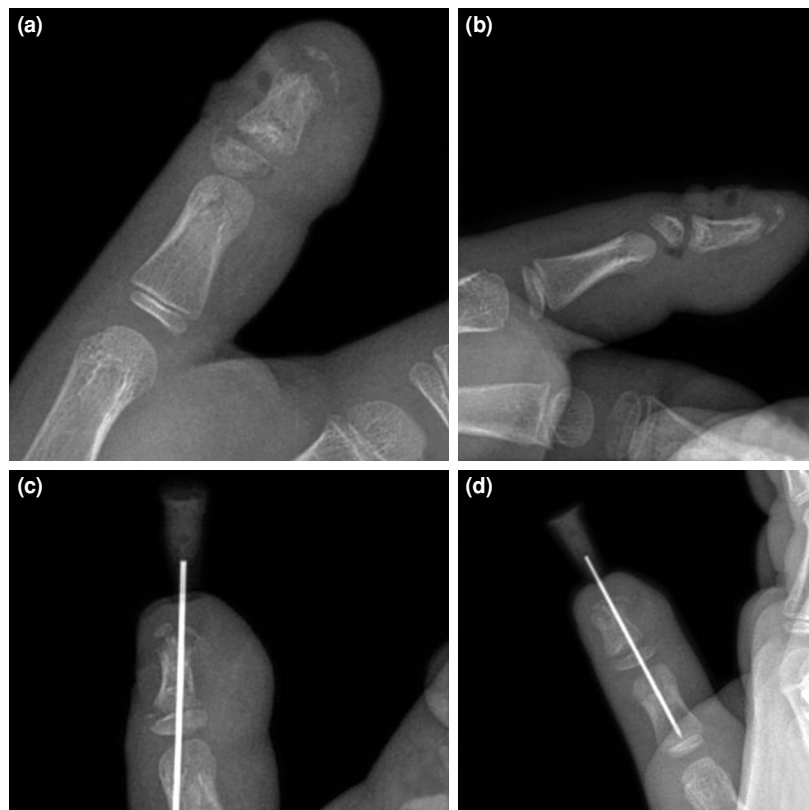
Anteroposterior and lateral X-rays of a 12-year-old patient with a Seymour injury to the 4<sup>th</sup> finger of the left hand.
